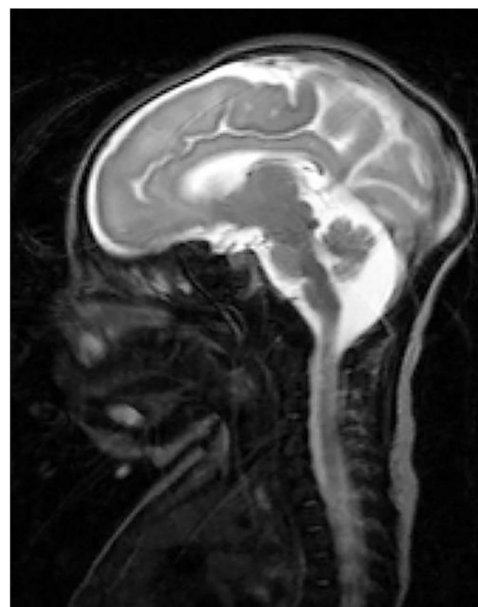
Magnetic resonance imaging scan revealing LCH.
